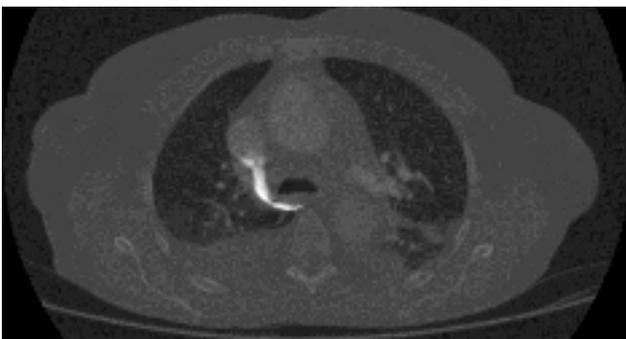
CT- angiography
